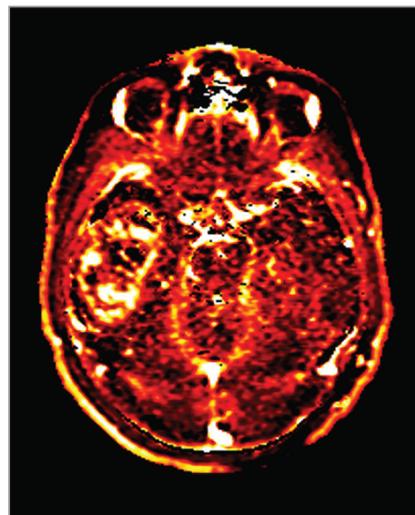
Figure above shows the results of various types of MRI scans taken on a patient with a glioma.
